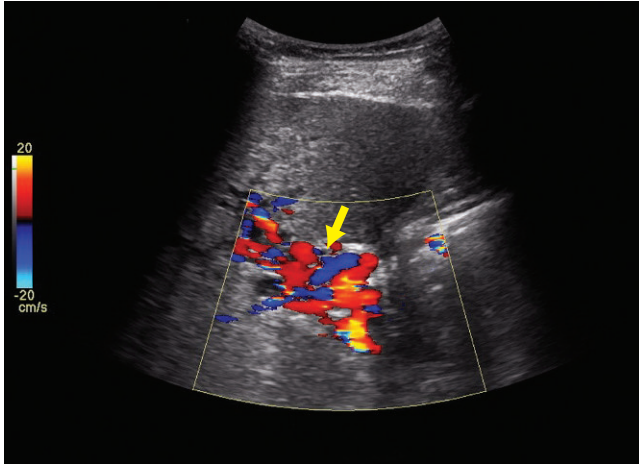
The color Doppler image of the porta shows multiple tubular channels (arrow) extending into the liver along the course of the thrombosed right portal vein. These tubular channels are red and blue because of the tortuosity of the venous collaterals, however, the overall direction of blood flow is toward (hepatopetal) the liver.
